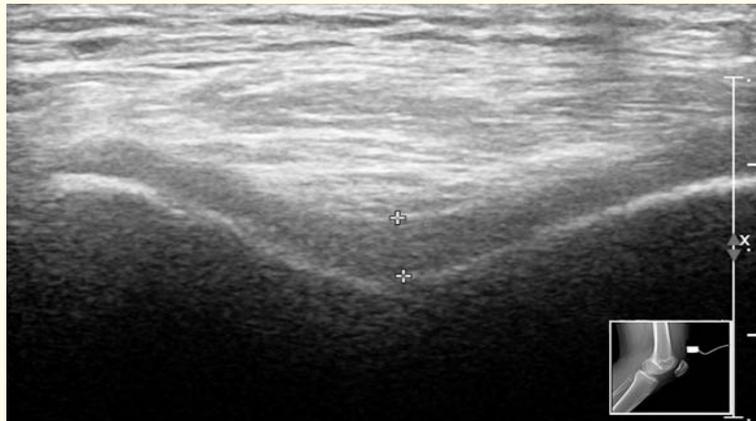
Knee ultrasound. Axial scan over the knee. A hypoechoic band (between the calipers) over the tibia normal cartilage.
